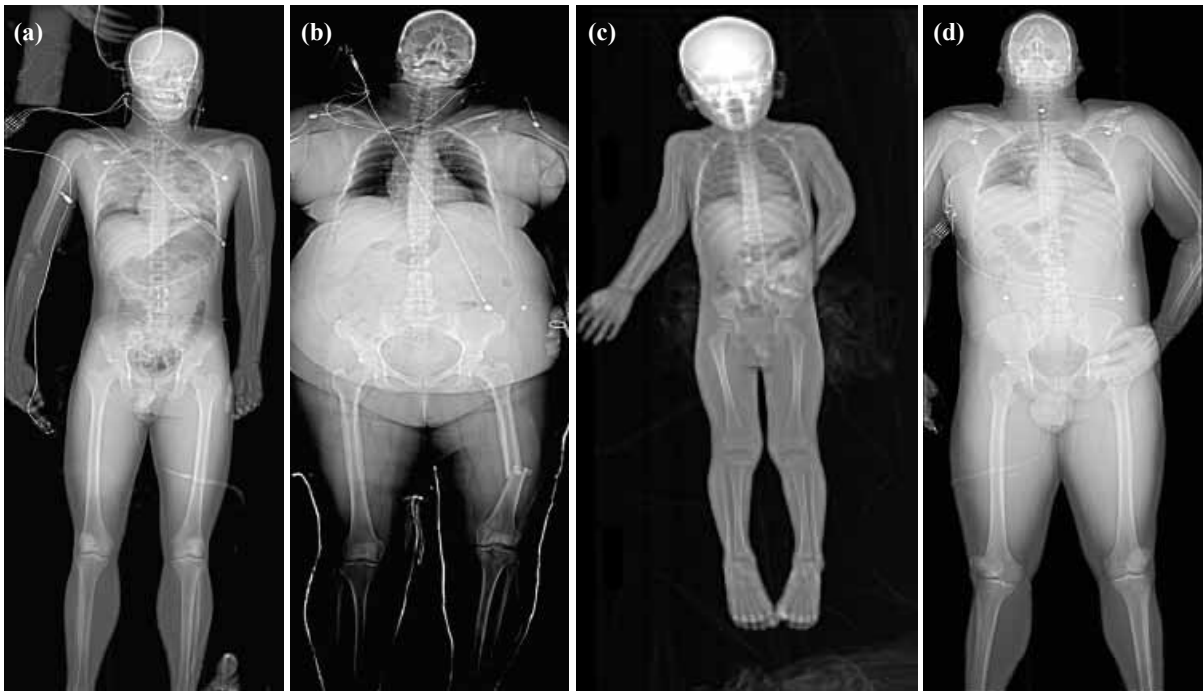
(a) A 30-year-old male with blunt chest injury after a motor-vehicle accident. The full-body Lodox® Statscan® (LS) demonstrates lung contusion. The image quality for delineating acute lung injury is recognized here. (b) A 48-year-old male with a left femur fracture. The LS provides increased radiological opportunities for bariatric patients. The weight capacity of the carbon-fiber bed accommodates patients up to 450 pounds. In addition, via a specialized algorithm, the machine tailors the amount of X-ray exposure required to image obese patients. In this way, the soft tissue penetration and bony detail is superior to conventional films. (c) A left humeral fracture in a pediatric patient. The LS has been used effectively in the pediatric population to quickly identify multiple bony injuries while limiting radiation exposure. (d) A 50-year-old male with multiple gun-shot wounds (GSW). Bullet fragments are visualized in neck and the right lower quadrant of the abdomen. Full body scanning is helpful in patients with multiple GSWs where comparing anteroposterior and lateral views can identify the potential trajectory of each bullet.
